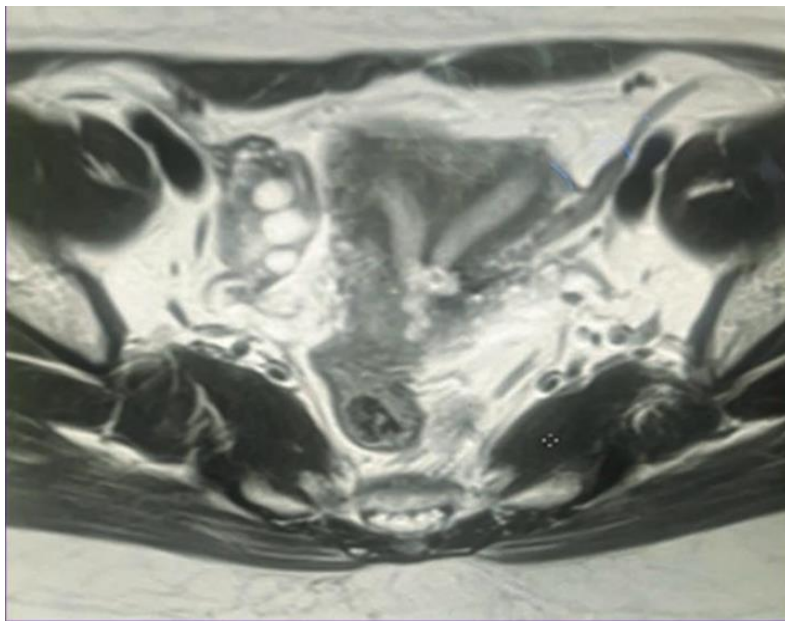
MRI Pelvis shows two discrete uterine horn with fundal cleft, widened inter cornual distance and communicating endometrial cavity in lower uterine segment.
